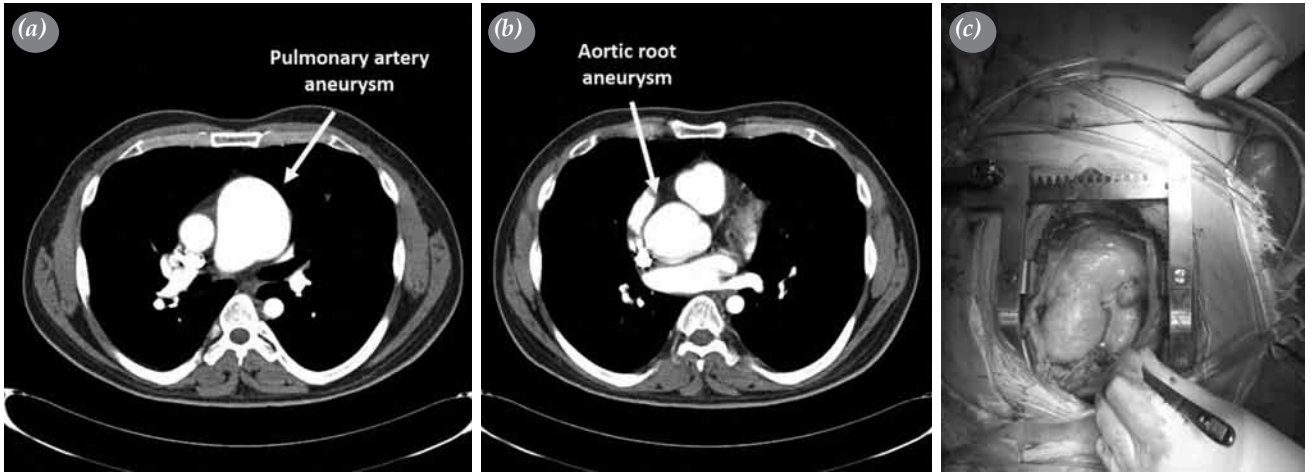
(a) A computed tomography angiography image of a pulmonary artery aneurysm, (b) aortic root aneurysm, (c) intraoperative view.
